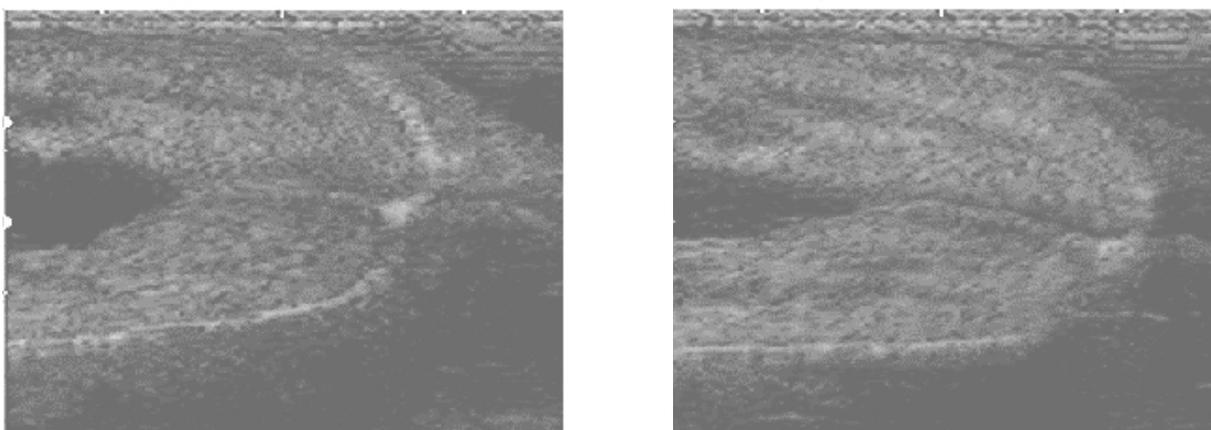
Ultrasound view of teat before and after milking.
